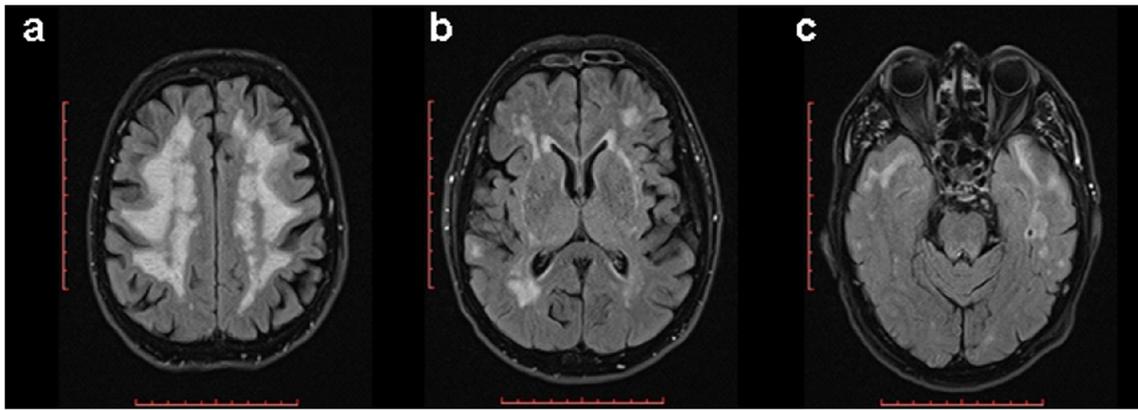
Brain MRI images of the proband's father. a Axial long TR sequences: bilateral, symmetrical, isolated, and confluent white matter hyperintensities extended to b external capsules and c temporal lobes
